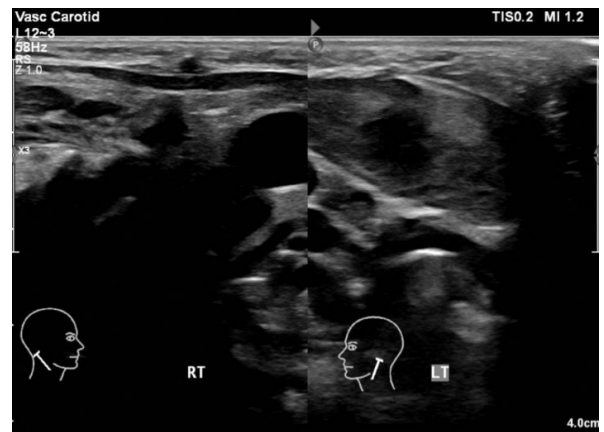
Ultrasound of the neck shows a fusiform dilatation within the SCM, measuring 1.1 × 3.9 cm at left neck as compared to the right neck, suggestive of FMC
